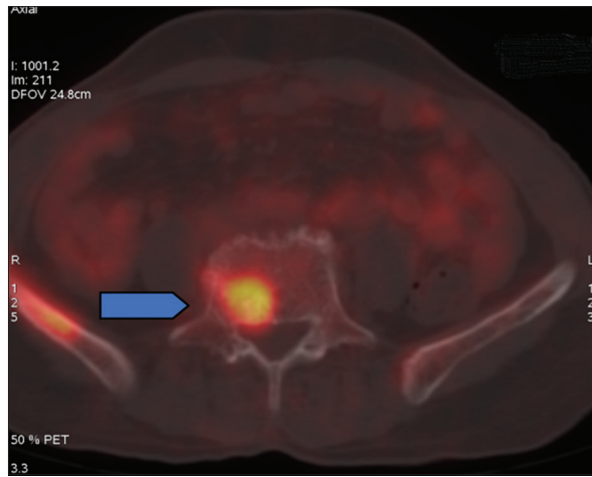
Positron emission tomography-computed tomography showing skeletal metastasis to lumbar vertebral body
